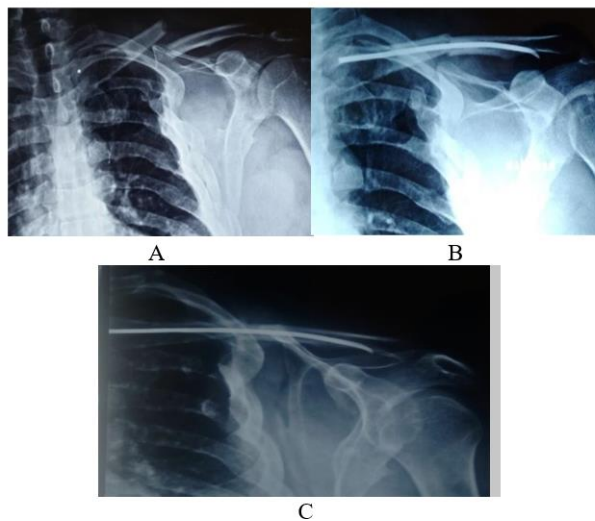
showed that A) Preoperative x-ray, B) Postoperative x-ray and C) X-ray after six months.
